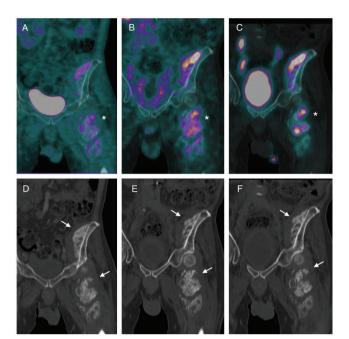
A complementary 3-phase bone scan was secondly performed. The bone scan showed extra-osseous extensive accumulations of technetium-99m (Tc-99m) hydroxymethylene diphosphonate matching with increased <sup>18</sup>F-FDG uptake areas. Coronal fused PET/CT image (A), coronal fused single photon emission computed tomography/CT images on soft-tissue phase (B) and on delayed phase (C), showing a matching tracer uptake between the two modalities in HO areas around the left hip (asterisks). On CT images, multiple areas of dense calcifications were seen (arrows, coronal CT images D, E, and F). HO is a diverse pathologic process, defined as the formation of extraskeletal bone in muscle and soft tissues, usually between the muscle and the joint capsule. The reported incidence of HO in patients with spinal cord injury is approximately 20% (1). Such development of neurogenic HO generally occurs within a few months after spinal cord injury and progresses over a period of years (2). Clinically, neurogenic HO may cause severe pain during the process of formation and adversely affecting quality of life (3). Three-phase bone scanning is a highly sensitive method for the assessment of progression, maturation process and extent of HO. An increased vascularity on angiographic flow and soft-tissue phases is the earlier sign. Then occurs Tc-99m methyl diphosphonate (MDP) accumulation on delayed-phase, which is often seen 4 to 6 weeks earlier than ossification (4). Threephase bone scanning could be required for the clinical management of HO. Indeed, conservative treatment such as medication or local radiotherapy could be performed over surgical excision in case of high Tc-99m MDP accumulation (5). <sup>18</sup>F-FDG uptake in HO, suggestive of active inflammation, is known as a pitfall of <sup>18</sup>F-FDG PET/CT imaging. The concern, especially in early cases is that the imaging findings on FDG PET/CT could mimic that of aggressive sarcomas (6,7,8). Elucidating the antecedent history becomes important in making the current diagnosis in these patients.
